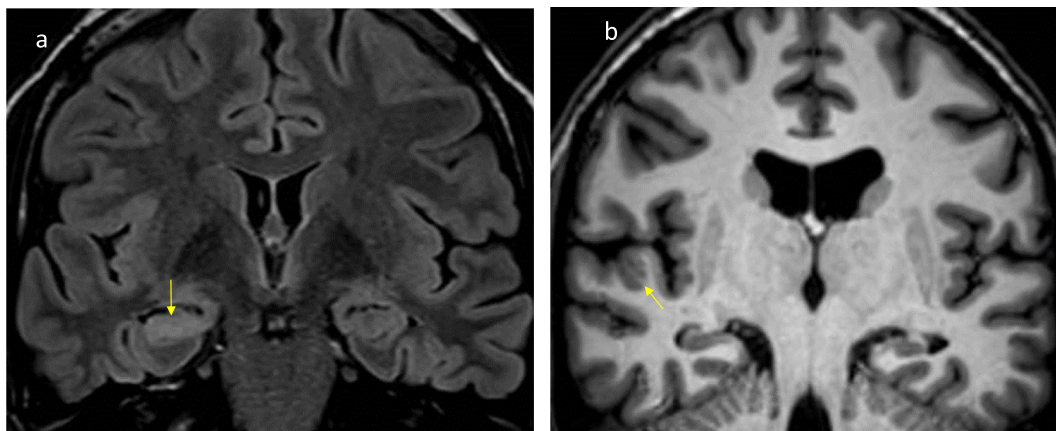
a,b. Dual pathology with mesial temporal sclerosis and localized perisylvian polymicrogyria in a 32 year old female. Coronal FLAIR (a), and T1 Inversion recovery image (b) through hippocampus. Marked signal increase in right hippocampus indicating gliosis with only subtle atrophy (a). Dual pathology is visualized by a localized area of undulated polymicrogyric thinned cortex with white matter digitations and fused surface layer representing localized polymicrogyria (b).
